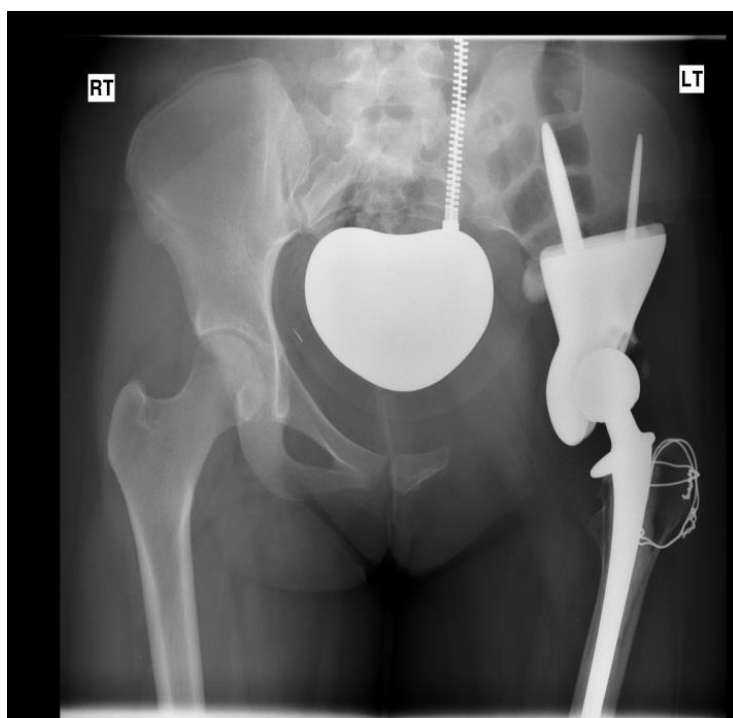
AP radiograph of the pelvis showing a type II resection and an endoprosthetic pelvic replacement
